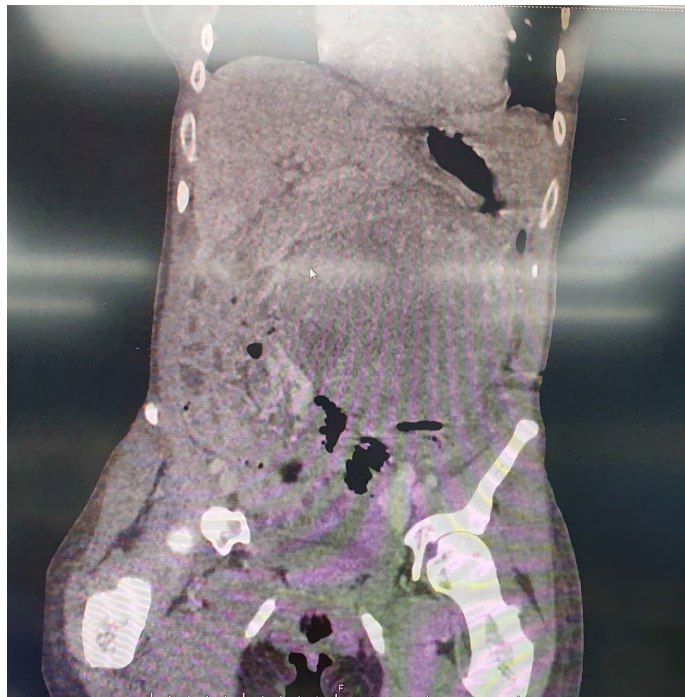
Abdominal CT revealing a 15 cm tumor in the liver
